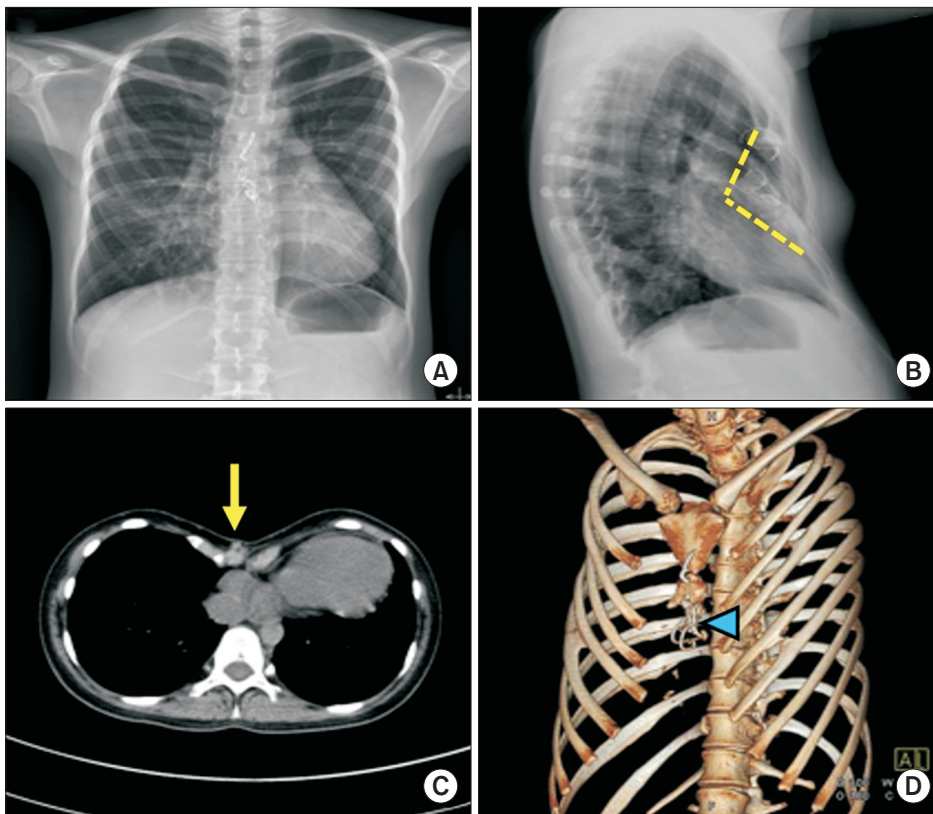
(A, B) Preoperative chest X-ray showing depression of the anterior chest wall. (C) Axial view of computed tomography (CT) showing a Haller index of 5.64 and an asymmetry index of 1.01 (arrow). (D) Preoperative chest CT 3-dimensional reconstruction showing previous sternal wiring and the anterior chest wall deformity (arrowhead).
